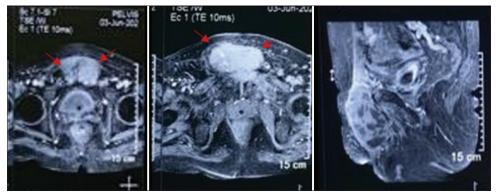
MRI pelvis showing an enhancing soft-tissue mass infiltrating into the pubic bone and adjacent muscles. MRI: Magnetic resonance imaging. Red arrows show locally infiltrating nature of the tumor
